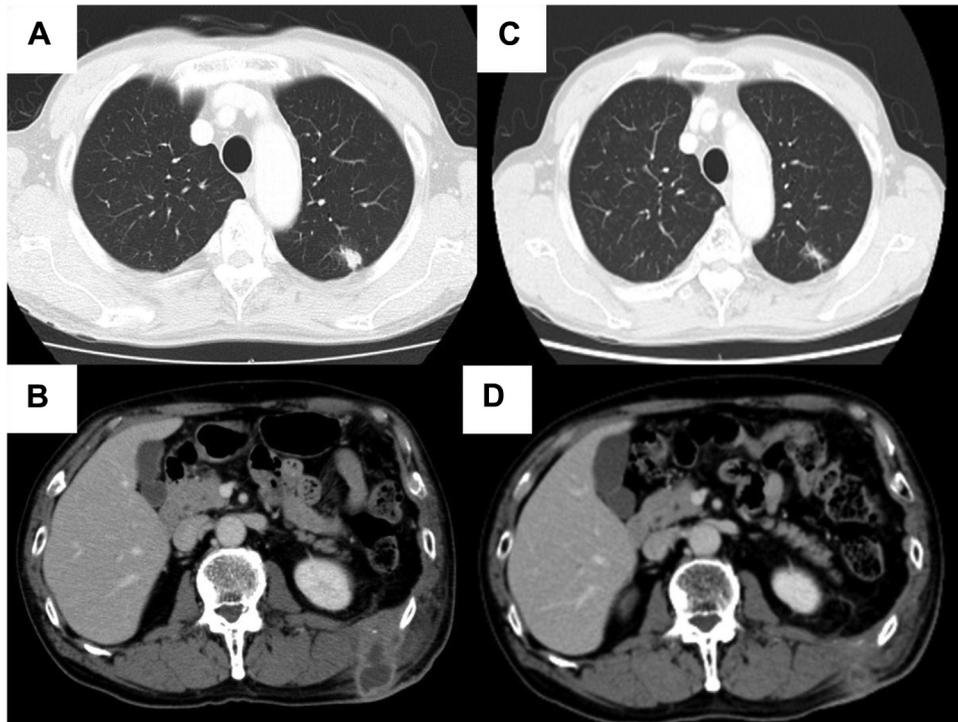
Computed tomography scan of muscle metastatic and primary lung lesions before (A and B) and 2 months after the initiation of nivolumab treatment (C and D).
